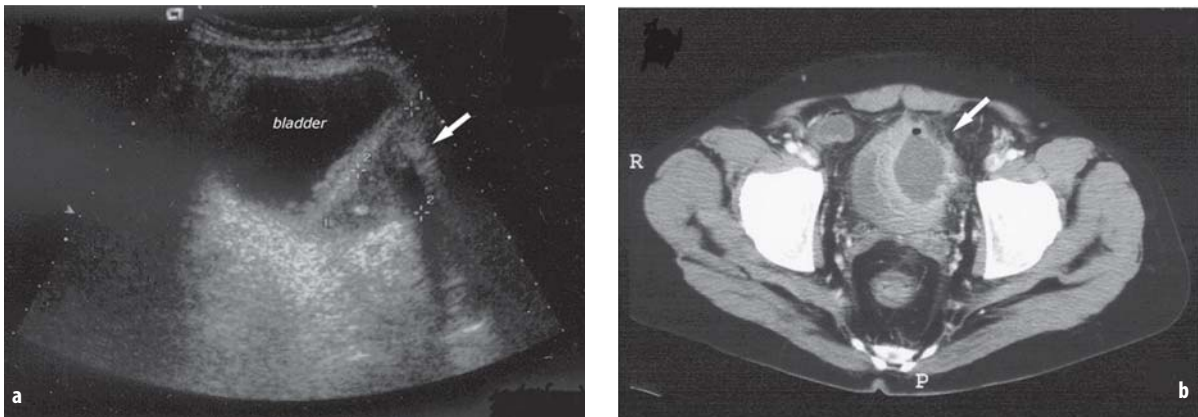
Ultrasound (a) and CT (b) images of a left perivesical abscess secondary to CD
